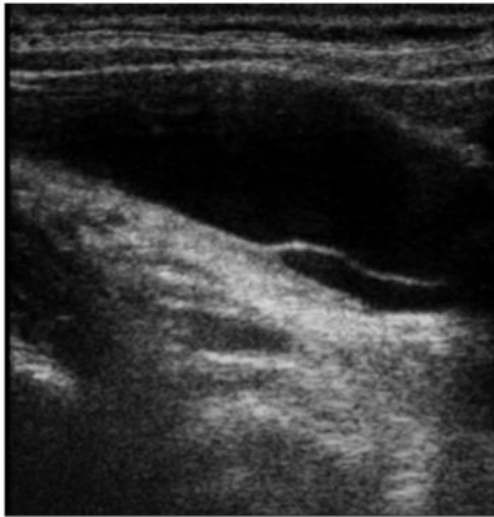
Visualization of the IJV in B-mode ultrasound in a normal control. Top, open jugular valve; bottom, valve closure.
